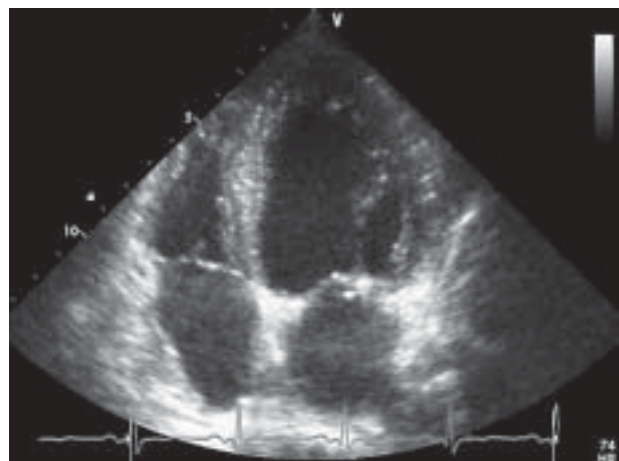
Transthoracic echocardiogram of patient after surgery
